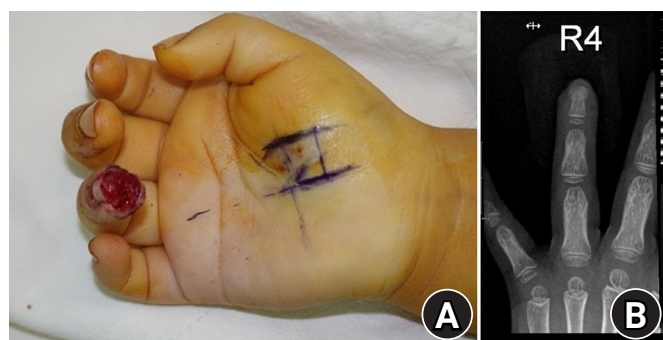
(A) Preoperative photograph of a 47-month-old female with a soft tissue defect (Ishikawa zone 1) and exposure of the distal tip of distal phalangeal bone at right ring finger. (B) Preoperative X-ray shows a minor fracture line in the distal phalangeal bone.
